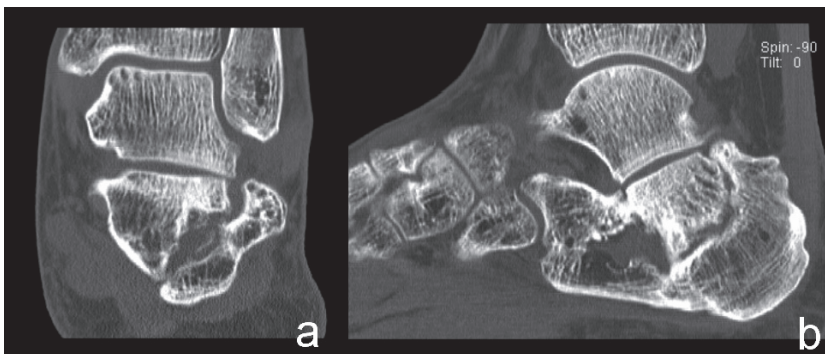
a, Case 1: Axial CT-scan image twenty-two months after percutaneous reduction and fixation showing nonunion; b, Sagittal view.
